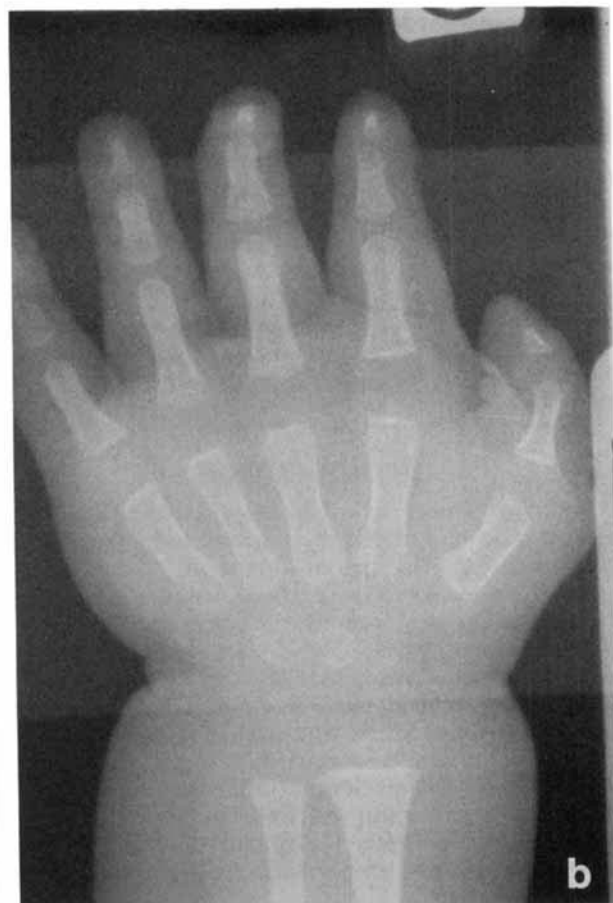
a: Patient 1. Note high forehead, flat bridge of nose, flat philtrum, apparently low-set ears, short neck, and large tongue. b: Hand. Note brachydactyly, and distal tapering fingers. Toes. Note big gap between first and the second toes, and abnormal nails. X-ray appearance of left hand. Note hypoplasia of distal and middle phalanges.
